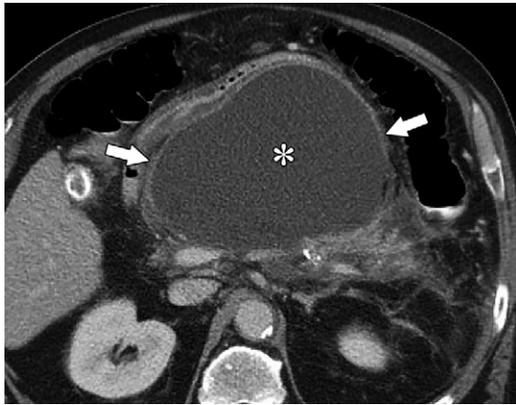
Pseudocyst in a 36-year-old man. Axial CT image obtained 6 weeks after onset of gallstone pancreatitis shows a large homogeneous fluid collection in the lesser sac (*) with no nonliquefied components and a thick enhancing wall (arrows), findings that are consistent with pseudocyst.
